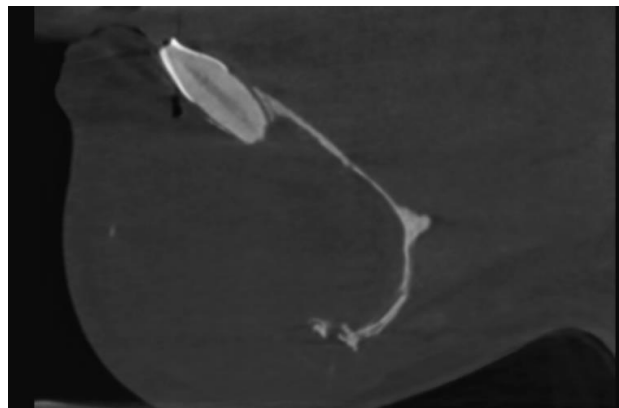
CBCT cropped sagittal section showing knife edge resorption wrt 31
